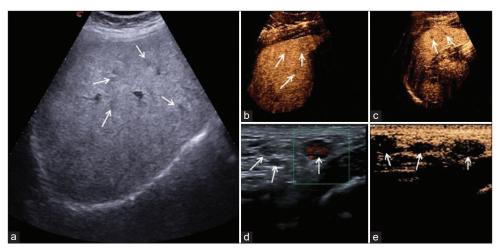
(a) Gray-scale ultrasound. The liver scans revealed blurred subcentimetric hypoechoic areas in all segments (arrows). (b) CEUS allows for better visualization of liver granulomas (arrows) that show sharper margins than grayscale examination. (c) CEUS shows granulomas with distinct margin in the spleen (arrows). (d) The gray-scale ultrasound shows enlarged mesenteric lymph nodes, some of which are highly vascularized. (e) CEUS allows for better detection of mesenteric lymph nodes that show sharper contours than gray-scale ultrasound, CEUS: Contrast enhancement ultrasound
